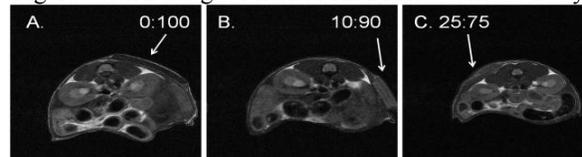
MRI images of PEGDA:HDDA networks at 6 weeks.
